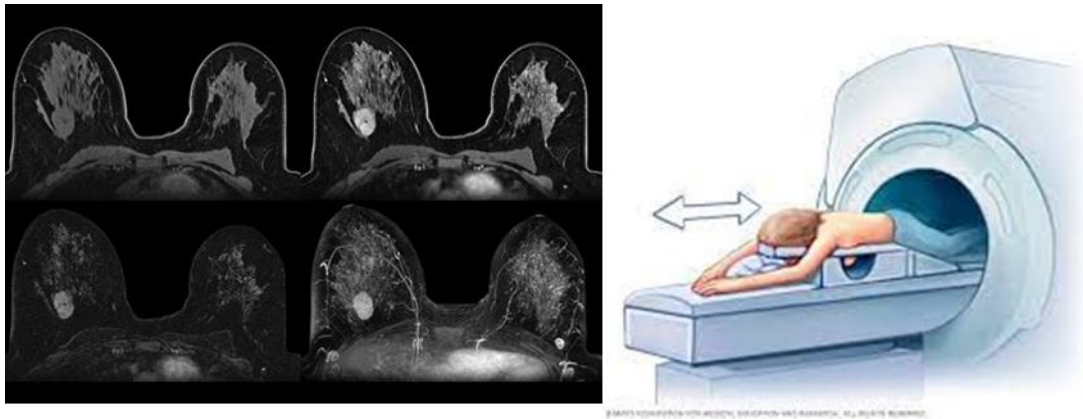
Breast MRI imaging (Source: <https://www.mayoclinic.org/tests-procedures/breast-mri/about/pac-20384809>)
